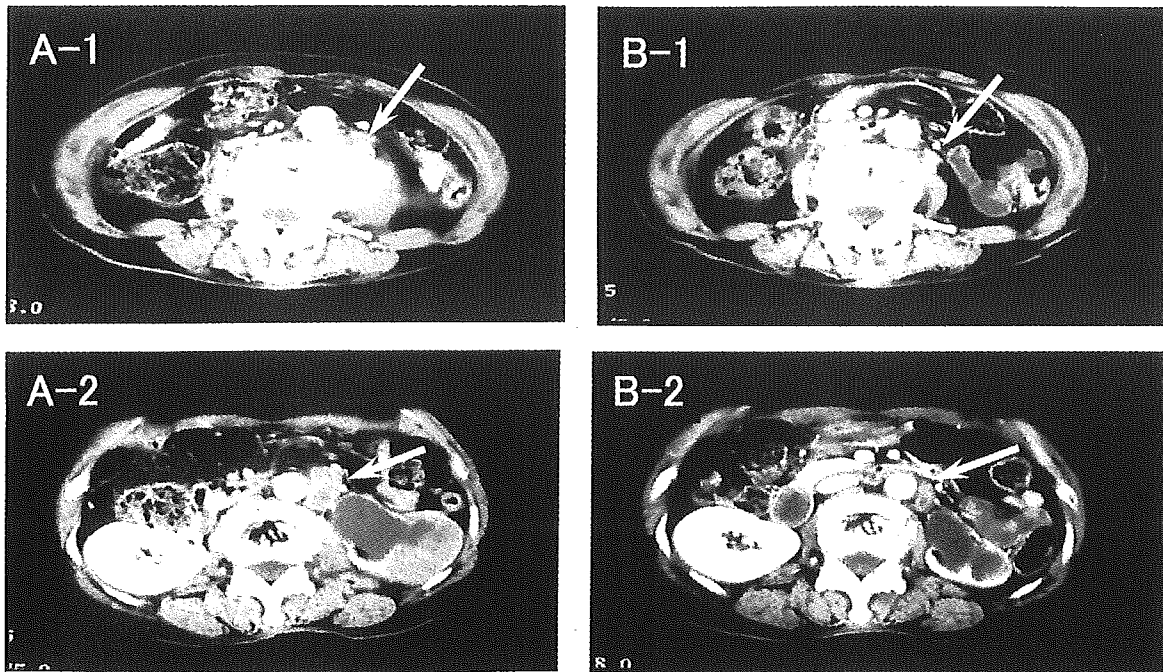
Computed tomography (CT) images before (A-1, A-2) and after (B-1, B-2) chemotherapy in case 2. The maximal diameters of ureteral tumor and para-aortic lymph node metastasis (A-2 and B-2, arrow) decreased from 5.0 to 3.2 cm and 3.0 to 2.1 cm, respectively.
